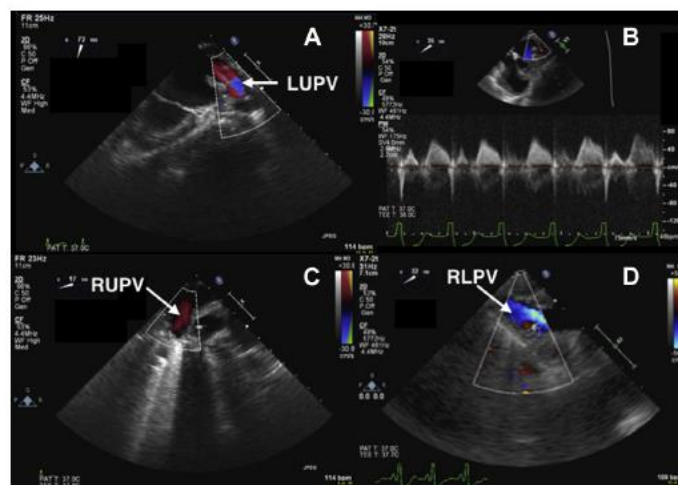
(A) Midesophageal view of the left upper pulmonary vein (LUPV) with color flow Doppler. (B) Pulsed-wave Doppler of the LUPV, displaying peak velocities less than 80 cm/s. (C) Midesophageal view of the right upper pulmonary vein (RUPV) with color flow Doppler. (D) Midesophageal view of the right lower pulmonary vein (RLPV) with color flow Doppler.
